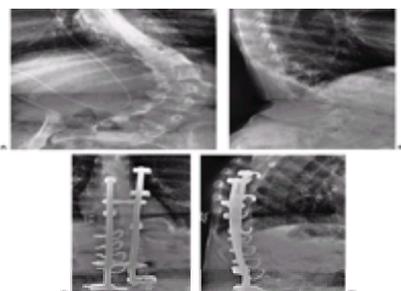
A mature 12-year-old girl with progressive lumbar scoliosis is an L4-level paraplegic, and is a community walker with ankle-foot orthoses and crutches. A: Anteroposterior radiograph shows 55-degree lumbar scoliosis from T10 to L3. There is a 20-degree compensatory curve from L4 to the sacrum. There is residual 30-degree pelvic obliquity. The last intact vertebral arch is L2. B: Lateral radiograph shows severe 120-degree lordosis, which is typical of the deformity associated with tethered cord. C: Anteroposterior radiograph shows correction of the scoliosis and pelvic obliquity. Pelvic screws are used to fix the distal end vertebrae at L5. The lumbosacral joint was left unfused to allow the patient enough pelvic mobility to continue walking. Release of the tethered cord was performed at the same time as the spine fusion. An anterior interbody fusion was performed from T9 to L5, without instrumentation. D: Lateral radiograph shows correction of the lordosis to 45 degrees and the achievement of a normal sagittal alignment. (From ref. 59, with permission.)
